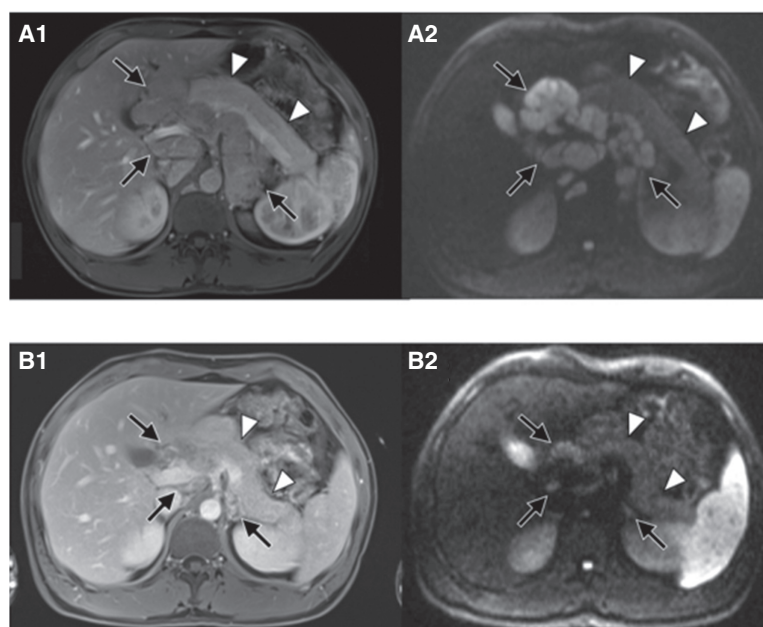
Almost complete remission at 3-mo follow-up after initiation of trametinib/dabrafenib. Baseline imaging: axial early venous phase MR image (A1) and axial diffusion weighted MR image with b-value of 800 sec/mm² (A2) show extensive lymphadenopathy in the retroperitoneum and liver hilum (black arrows). There is no lesion in the pancreas (white arrowheads). Follow-up imaging: Axial early venous phase MR image (B1) and axial diffusion weighted MR image with b-value of 800 sec/mm² (B2) show marked reduction of lymphadenopathy (black arrows). Still there is no lesion in the pancreas (white arrowheads).
